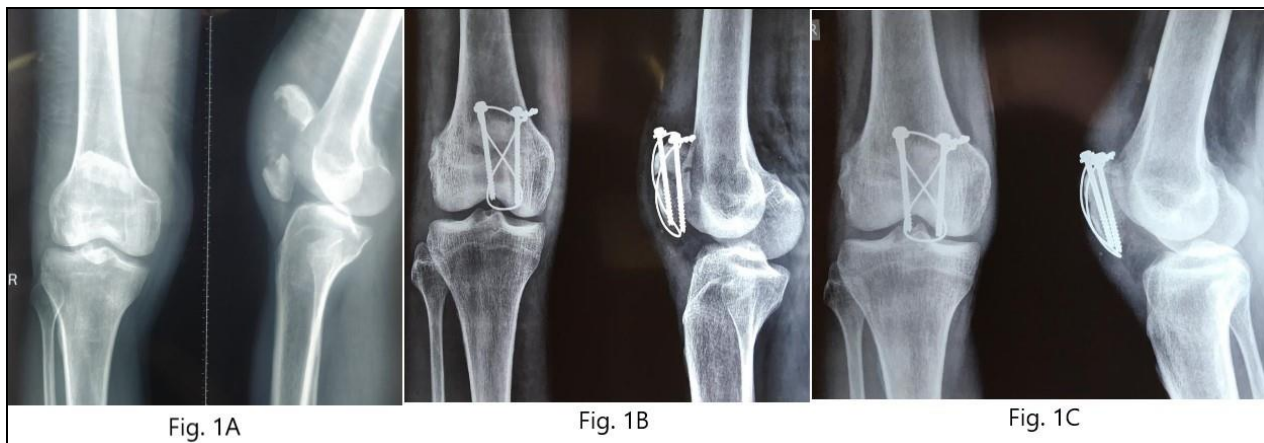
A) Pre-op xray, B) immediate post-op xray, C) xray showing bony union
